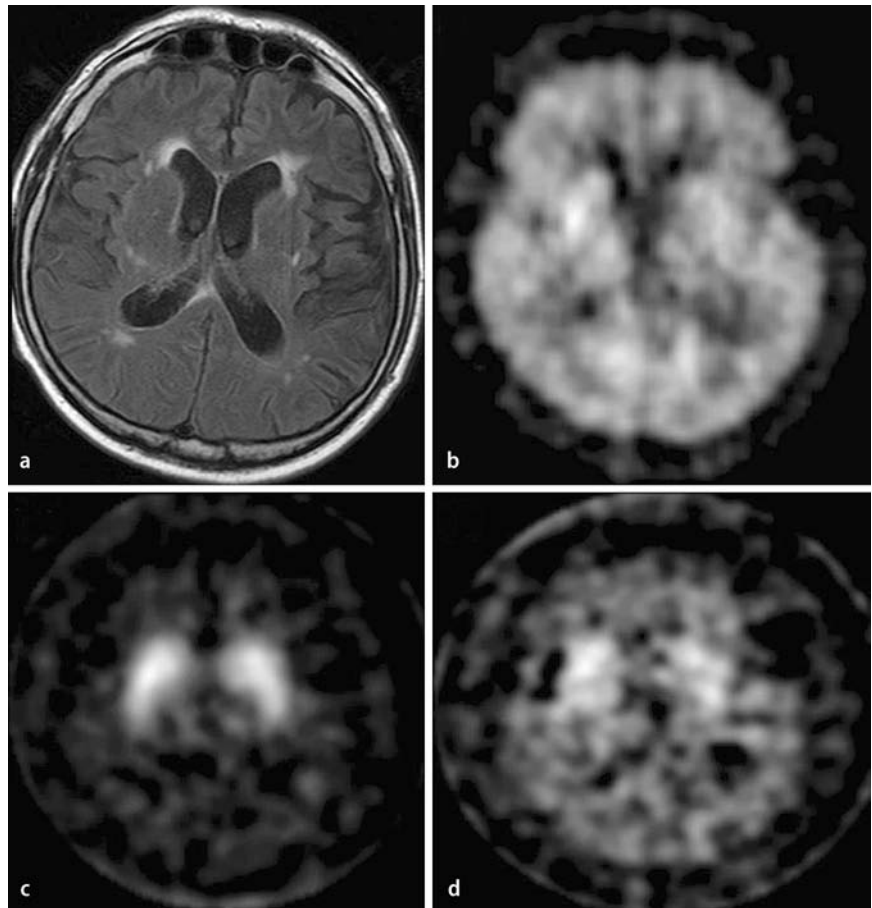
Transverse images at striatal level. A MR T2w FLAIR image shows coalescent lesions in the white matter and subcortical atrophy suggestive for microangiopathic leukoencephalopathy. We found a more extensive involvement of the superior frontal region and small lesions in the external capsule – involvement of these regions has a higher sensitivity and specificity for CADASIL B [^{18}F]FDG-PET of brain glucose metabolism is reduced in the thalamus and temporal cortex bilaterally as well as in the left striatum. C [^{123}I]FP-CIT SPECT of striatal dopamine transporter availability (left striatum 8.2, right striatum 8.0 – lower limit 4.6) and D [^{123}I]IBZM SPECT of striatal dopamine D2/D3 receptor availability (left striatum 2.2, right striatum 2.3 – lower limit 1.58) show normal values within the age range indicating functional integrity of the nigrostriatal dopaminergic system as described for vascular parkinsonism
